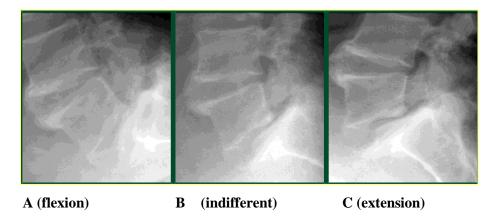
Meyerding's first degree spondylolisthesis radiographic control of the degree of stability in flexion- extension. A) flexion, B) indifferent, C) extension.
